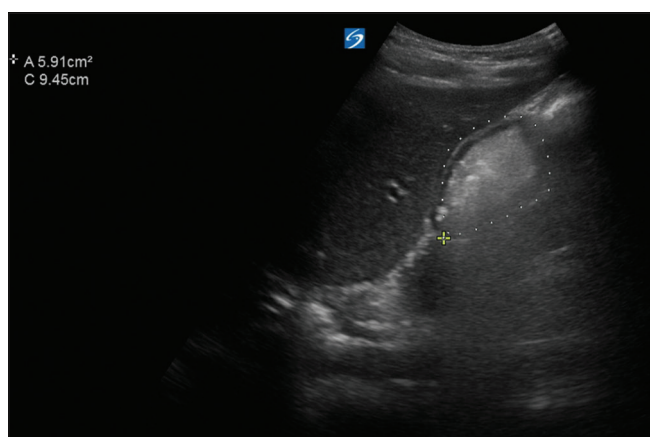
Gastric point-of-care ultrasound image showing solid/thick fluid in the gastric antrum suggestive of recent food ingestion. The cross-sectional area of the gastric antrum was calculated to be 5.9 cm². Based on the grading system for gastric antrum assessment, she was classified as a high risk for potential aspiration
